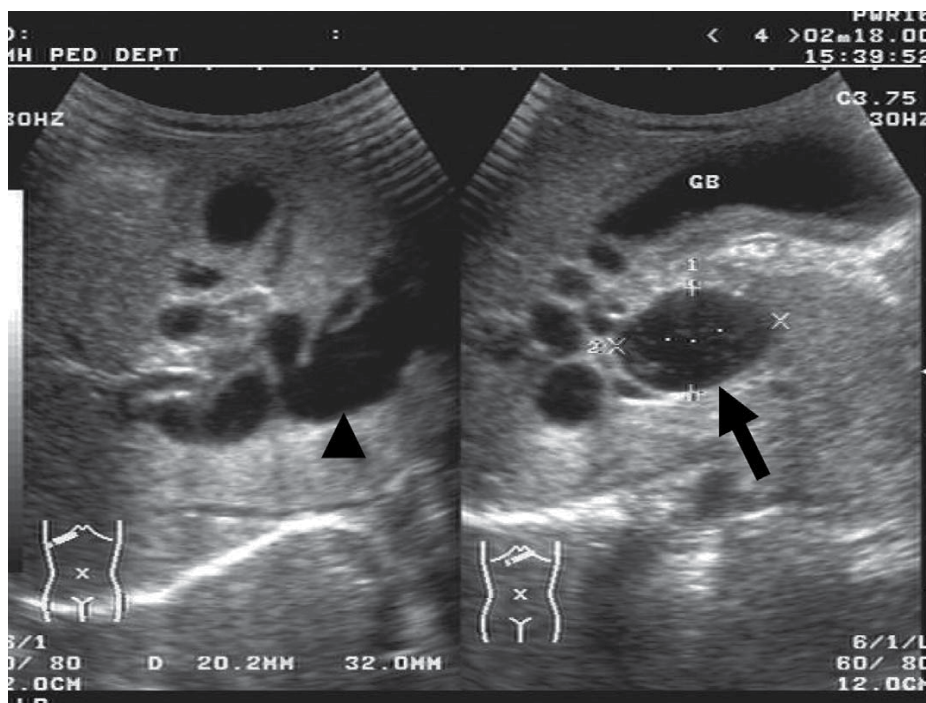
Choledochal cyst Type IVa: a common bile duct cyst (arrow) with intrahepatic duct dilatation (arrowhead). GB=gallbladder. (From Lee HC: *J Med Ultrasound* 2007;15(3):191-196.)
